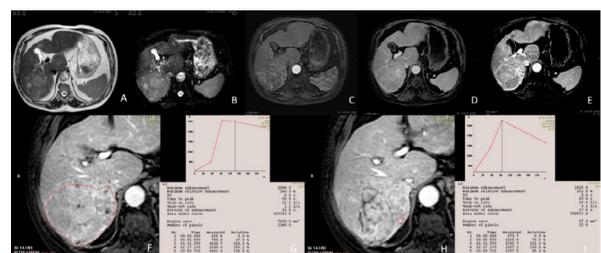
Hepatocellular carcinoma: (62 years-male) A-TSE T2A, B- DWI b 1000, C, D, E- Lesion in dynamic series, F, G- Time-intensity curve and semiquantitative analysis values of the whole lesion in arterial phase in dynamic series, H, I- Time-intensity curve and semiquantitative analysis values of the partial lesion in dynamic series
